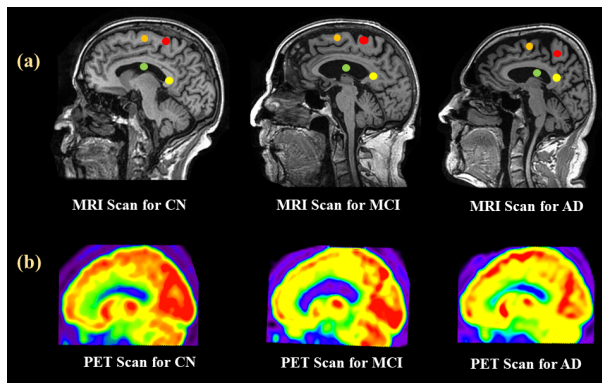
a) Structural changes using MRI imaging, GREEN Dot denotes the volumetric change of ventricles, YELLOW dot denotes the change in the hippocampus region, ORANGE marked denotes changes in white matter, RED denotes the structural change of grey matter b) Metabolic changes using PET imaging
